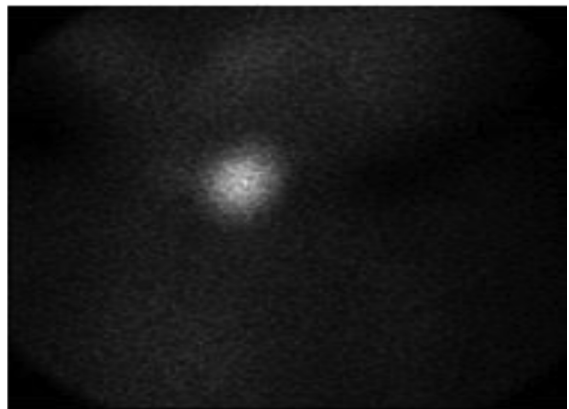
Tc99-m scintigraphy. Nuclear activation is only seen in right thyrold lobe
